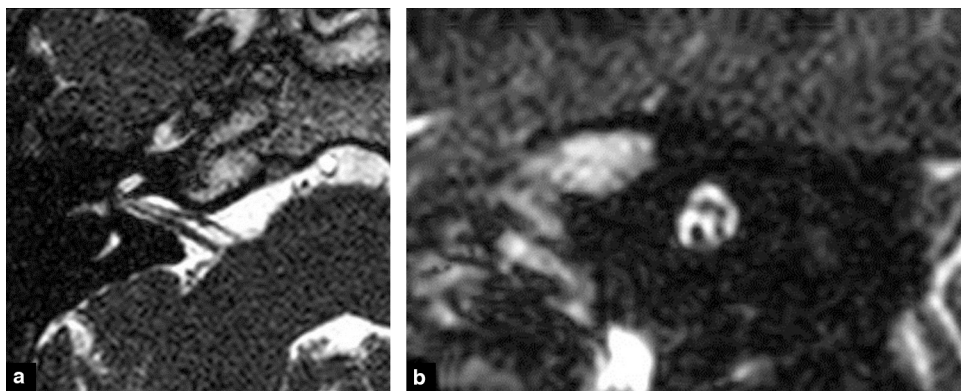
MRI in CISS sequence centred on the internal acoustic meatus. a: axial section revealing the facial nerve in anterior situation within the acoustico-facial; b: oblique sagittal section perpendicular to the axis of the IAM, the facial nerve is in anterior-superior position, the cochlear nerve in anterior-inferior position, the superior and inferior vestibular nerves behind.
